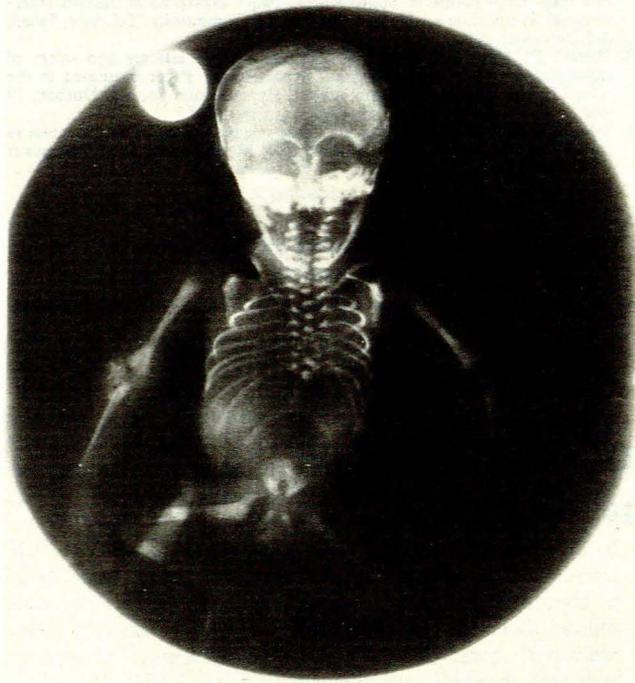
Radiograph of abortus. Note hemivertebra C1, fusion of lower thoracic vertebrae and absence of cord distal to this, and absence of pelvic bones except for ischial tuberosities and sacral alae.
